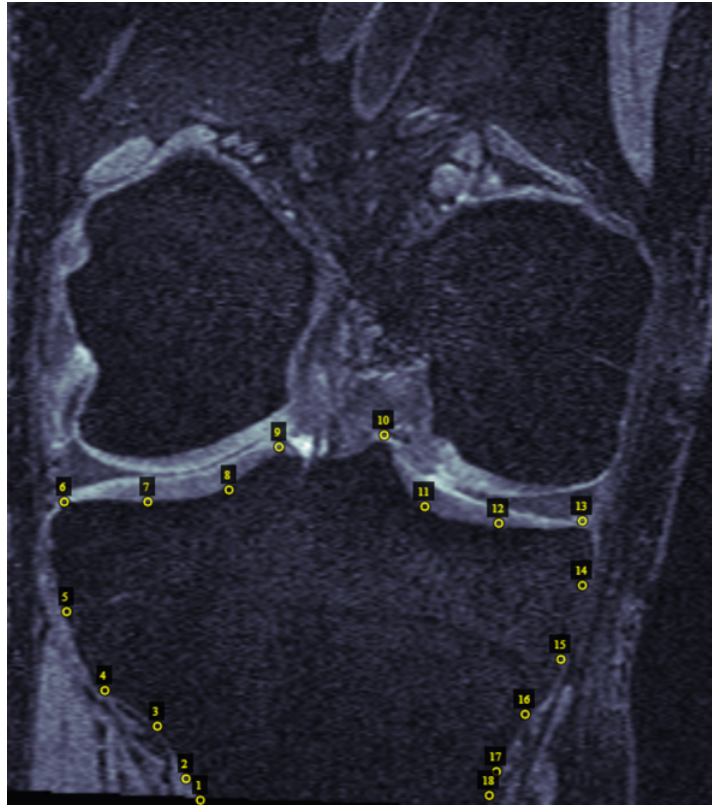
One example of annotated MR image. 18 landmarks were selected on the edge of tibia. The annotation was performed by VGG Image Annotator [77, 78].
